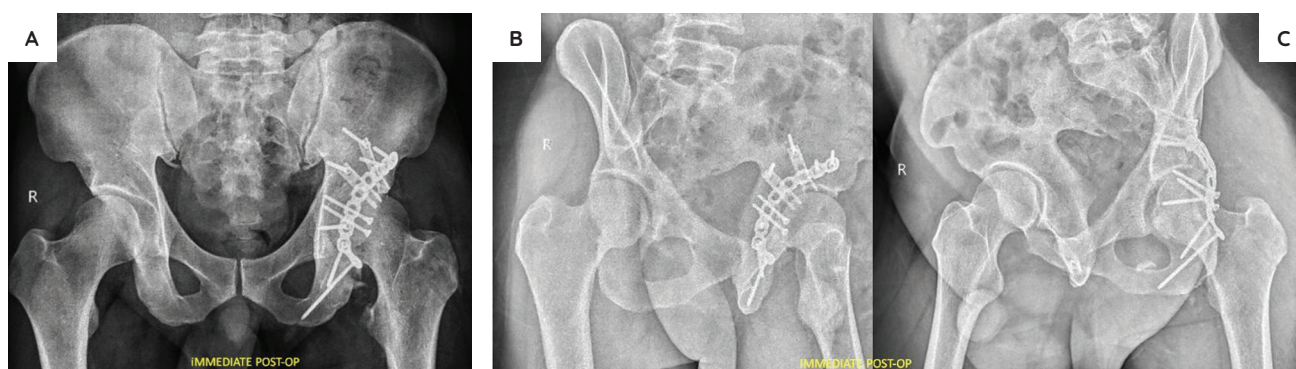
Immediate post-op x-ray after ORIF in AP (A) and Judet views (internal obturator and external iliac oblique) (B and C).
